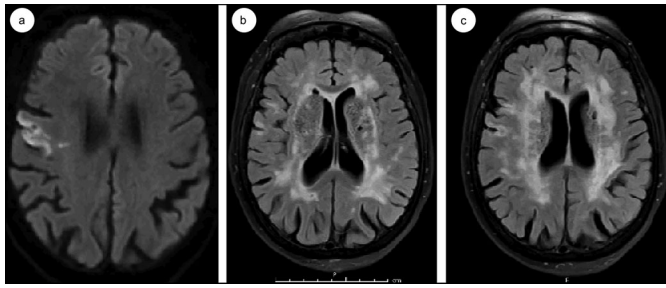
Patient MRI showing (a) acute infarction of the right frontal operculum and (b, c) encephalomalacia on the right frontal lobe and extensive leukoaraiosis on the bilateral subcortical white matter.
